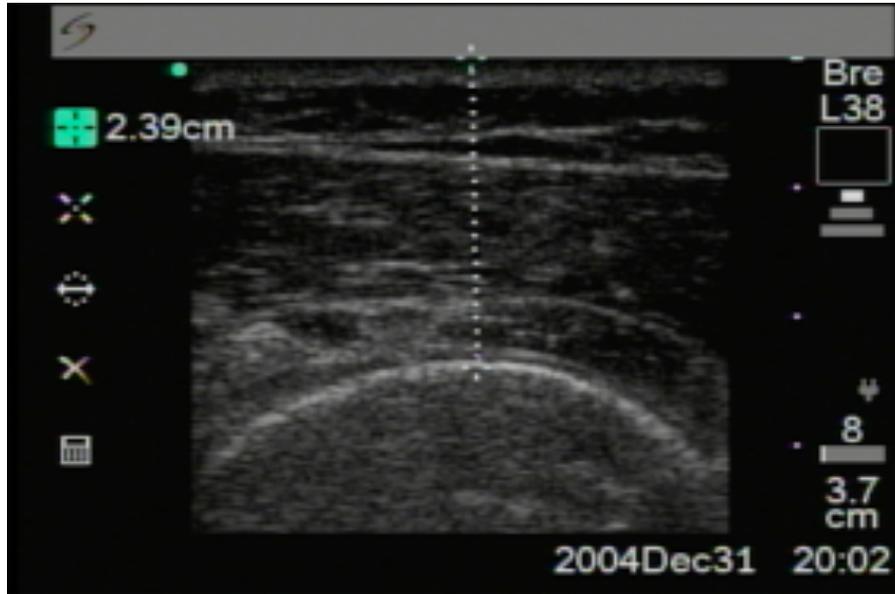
Ultrasound image of the humeral head in the horizontal plane
